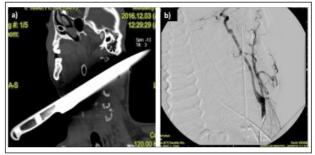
(a) CT scan documented presence of a knife with right-hand entrance in the lateral region of the neck, at the level of a plane passing anteriorly through the corpus of C3 and moving laterally beyond the median structures; (b) Angiography study demonstrated anatomical preservation of the vascular structures.
